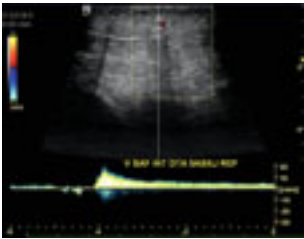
Triplex imaging: B-mode, colour-doppler mode and spectral-doppler mode of the GSV: insufficient. Reflux longer than two seconds with no dilatation. The transducer is in the transverse plane, angled towards the head of the patient.
